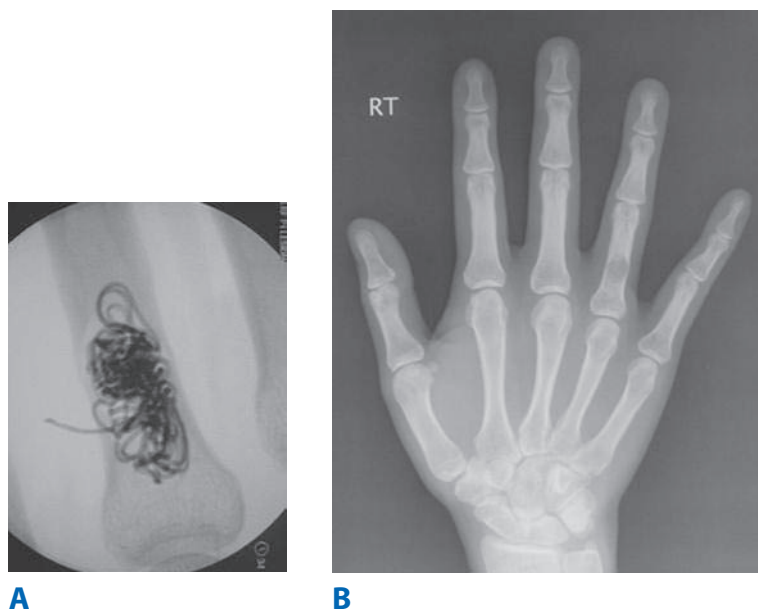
Enchondroma. A. X-ray of the phalanx demonstrates a well-defined central lucency. Surrounding cortex may thin or thicken. Thinning of the cortex contributes to risk of pathologic fracture. B. Intraoperative fluoroscopy after curettage of the tumor. A radiopaque ribbon is used to occupy the defect to help ensure that there is no tumor (similarly radiolucent to the defect after curettage) left behind prior to bone grafting.
